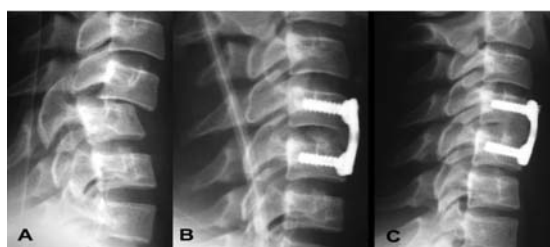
Patient number 12. (A) Preoperative X-ray image showing a B1-type, Frankel D injury at C4-C5. (B) Early postoperative X-ray image of the same injury showing reduction and anterior fixation. (C) Postoperative control, after 3 years, showing arthrodesis union, keeping initial reduction.
